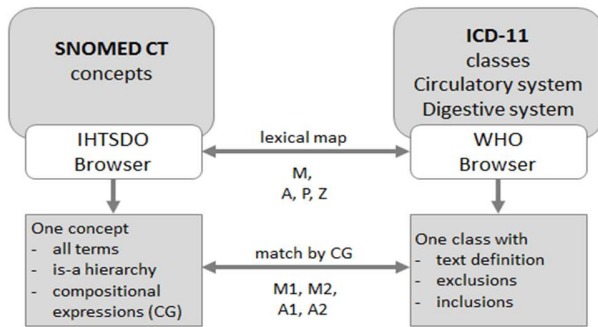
ICD-11 SNOMED CT semantic alignment principle
